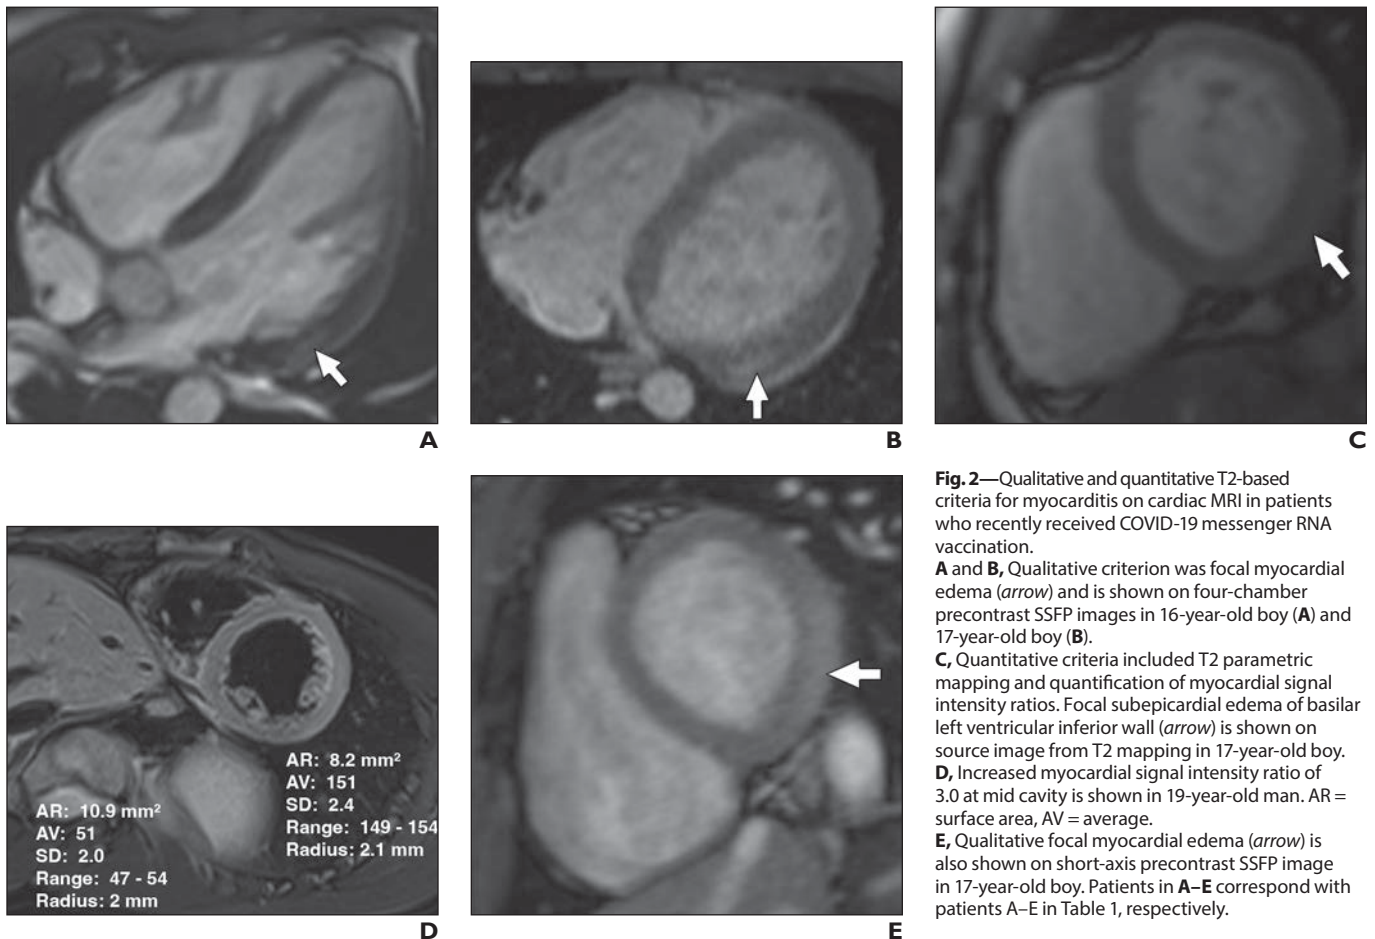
Qualitative and quantitative T2-based criteria for myocarditis on cardiac MRI in patients who recently received COVID-19 messenger RNA vaccination.
